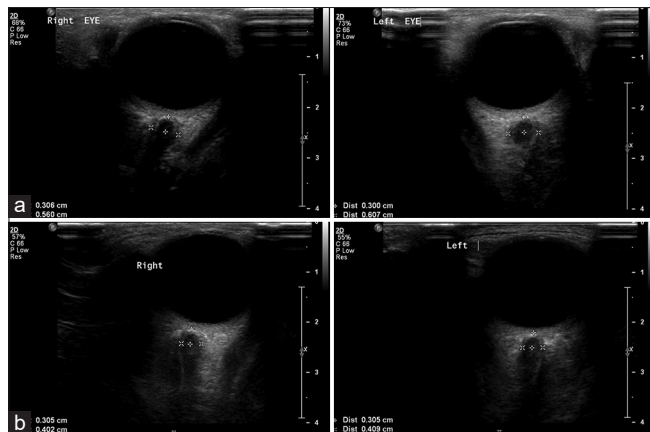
(a) Transorbital ultrasound showing increased optic nerve sheath diameter (ONSD) 3 mm posterior to inner scleral surface; 5.6 mm in the right eye and 6 mm in the left eye. (b) Transorbital ultrasound at follow-up showing normalization of ONSD; 4 mm in both eyes
